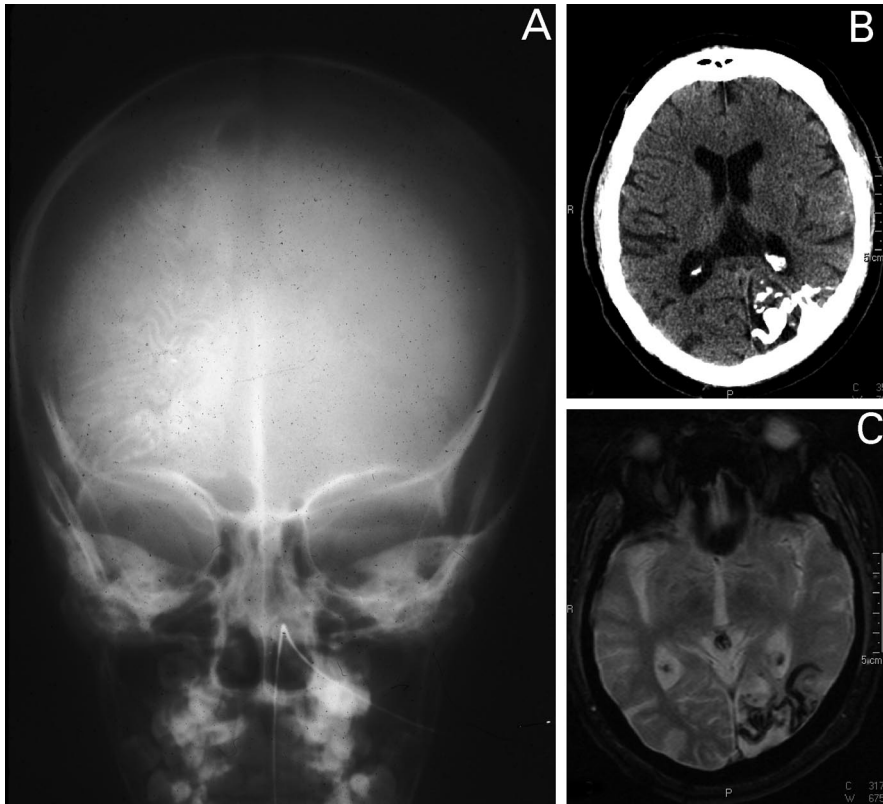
(A) A-P skull film that demonstrates the gyral calcifications of the subarachnoid angiomas of Sturge-Weber syndrome, tortuous parallel “tram tracks” across most of the right hemisphere. (B) In another patient, uncontrasted axial CT and (C) gradient-echo axial MRI show gyral calcifications, atrophy, and gliosis of the underlying cortex due to leptomeningeal involvement.
